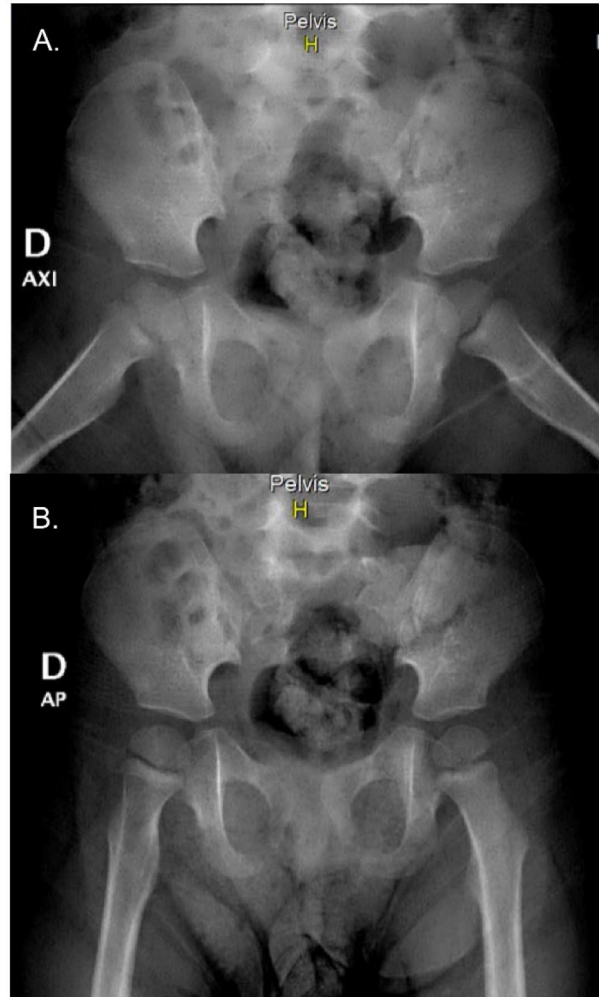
Radiographic study: pelvic images.
